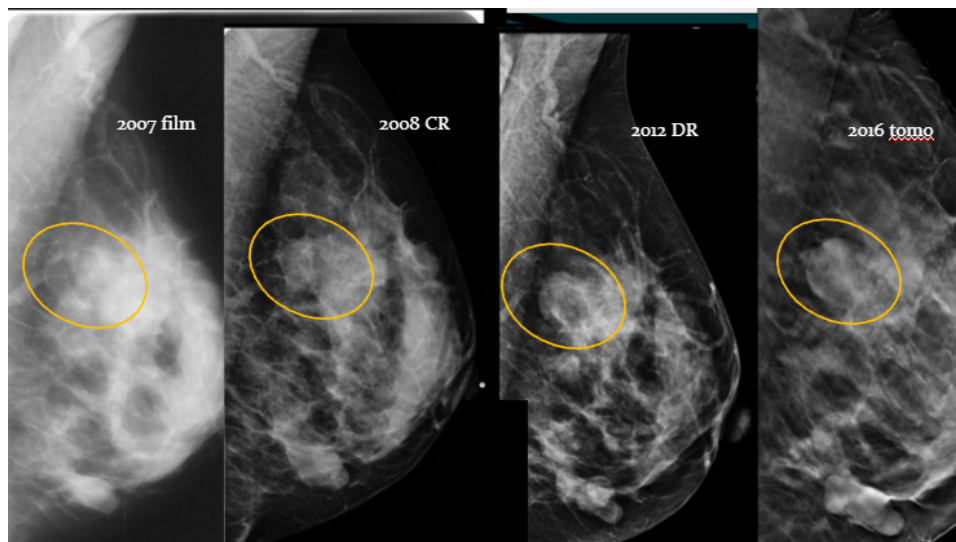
The improvements in technology and what they look like. All of these mammograms, performed between, 2007 and 2016, are relatively recent in comparison to the RCTs, the latest of which was performed in 1991. The 2007 mammogram was screen-film technology, 2008 was CR (an early digital format), 2009 was DR (a current 2D format) and 2016 is a tomosynthesis mammogram. There's a large benign mass in the lower half of the image, which becomes better circumscribed over time, demonstrating increased specificity. In the upper half of the image there is a more subtle mass, which was present at all these mammograms (documented sonographically), but became mammographically visible with the improvements in technology, demonstrating increased sensitivity.
